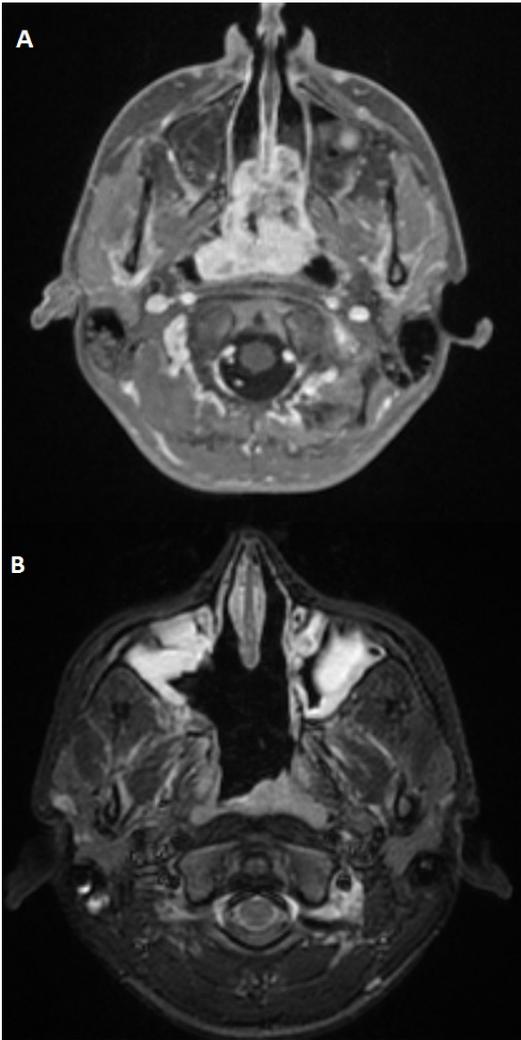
A) Preoperative postcontrast, T1 axial MRI scan. B) Postoperative, T2 axial MRI scan.
